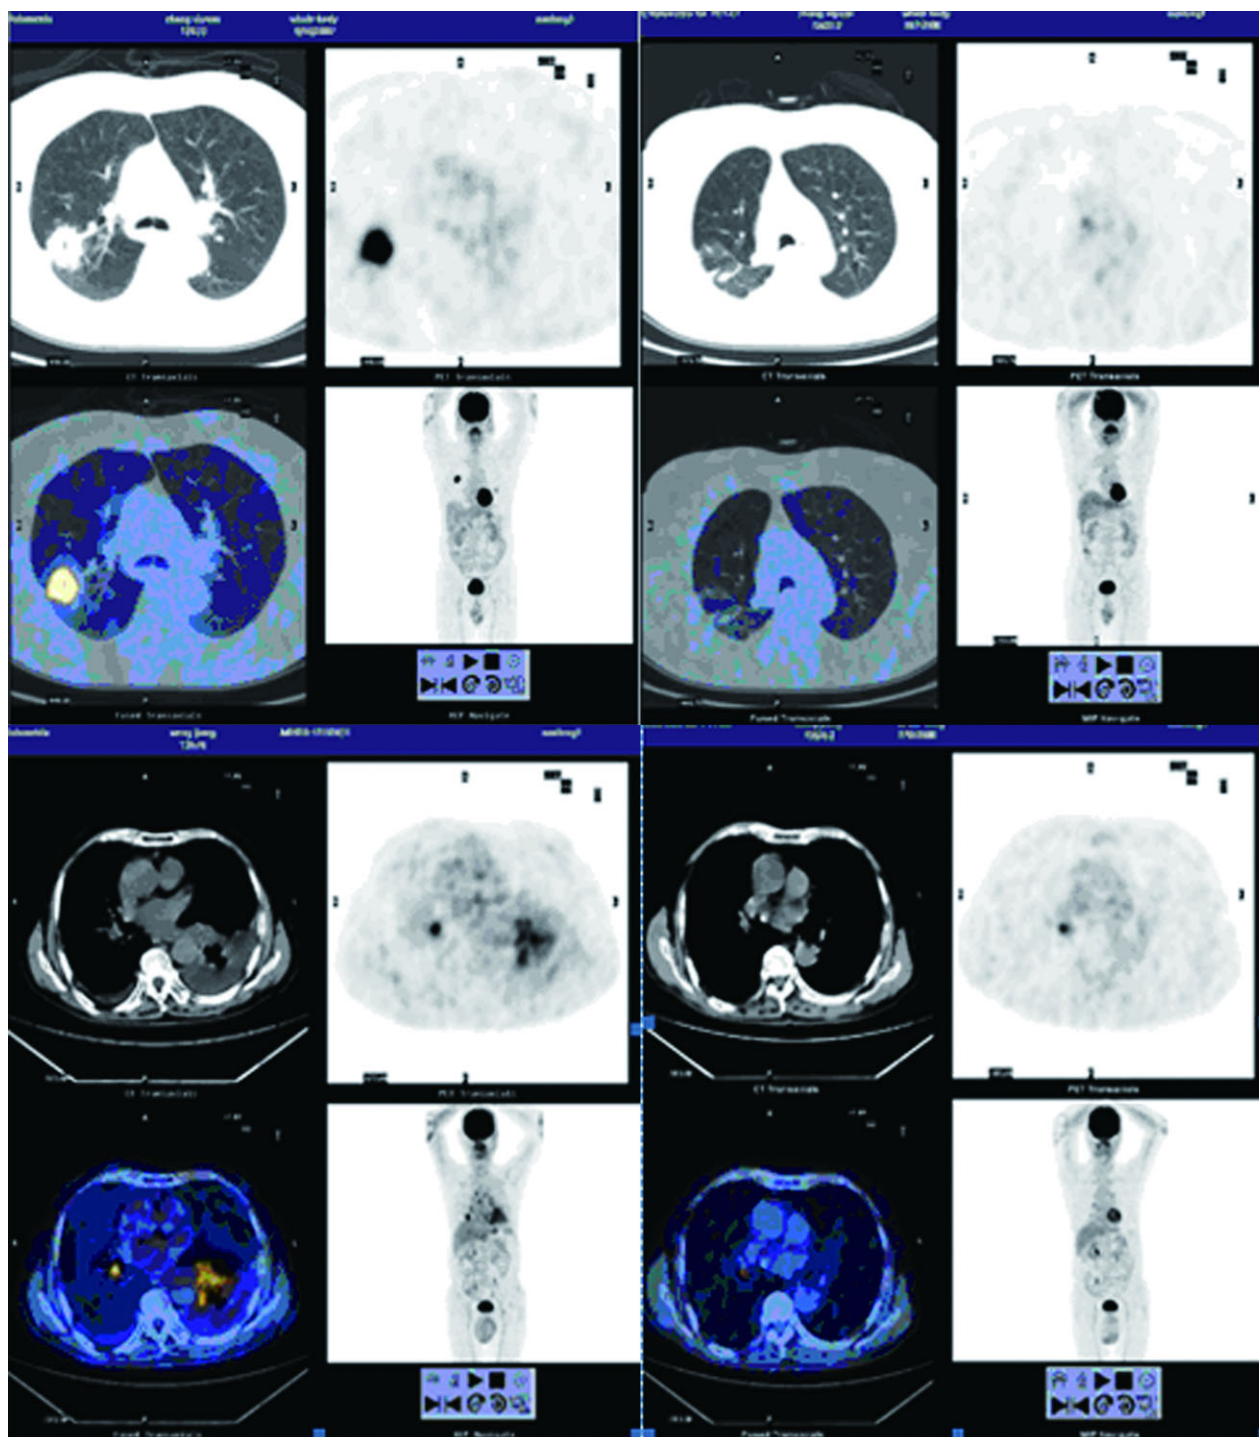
Positron emission tomography-computed tomography (PET-CT): standard uptake value (SUV) dramatically drops after six months of treatment with gefitinib.
